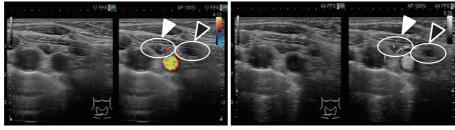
Ultrasonography imaging comparing CDU and DFI A finer blood flow is visualized in DFI than in CDU. Case 1: (A) (B) (C); blood flow is present in the parathyroid adenoma (white arrowheads) but not in the parathyroid cyst (black arrowheads) located near the parathyroid gland. Case 2: (D). CDU, color doppler ultrasonography; DFI, detective flow imaging
